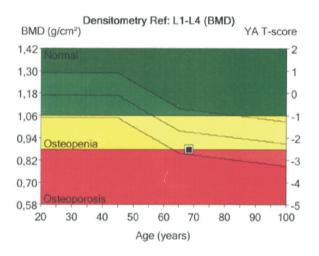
Dual-energy X-ray absorptiometry scan result showing BMD for the L1-L4 spinal region, plotted against age with a T-score of approximately –2.5, indicating osteoporosis. This influenced perioperative management and the decision to initiate antiresorptive therapy.
